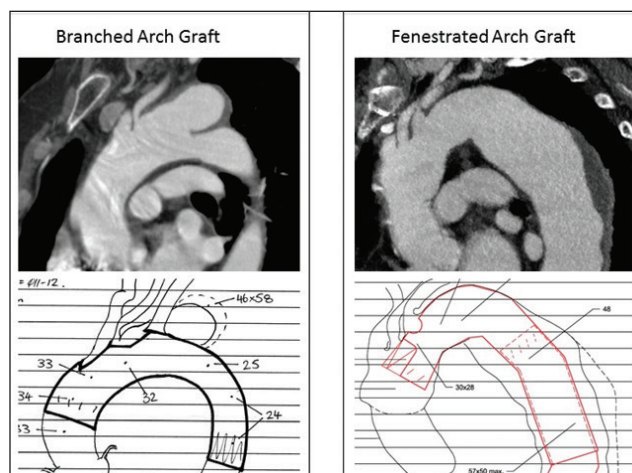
Sagittal reconstructions of CTA and preoperative planning sketches of patients with arch aneurysms planned to undergo fenestrated or branched TEVAR.
